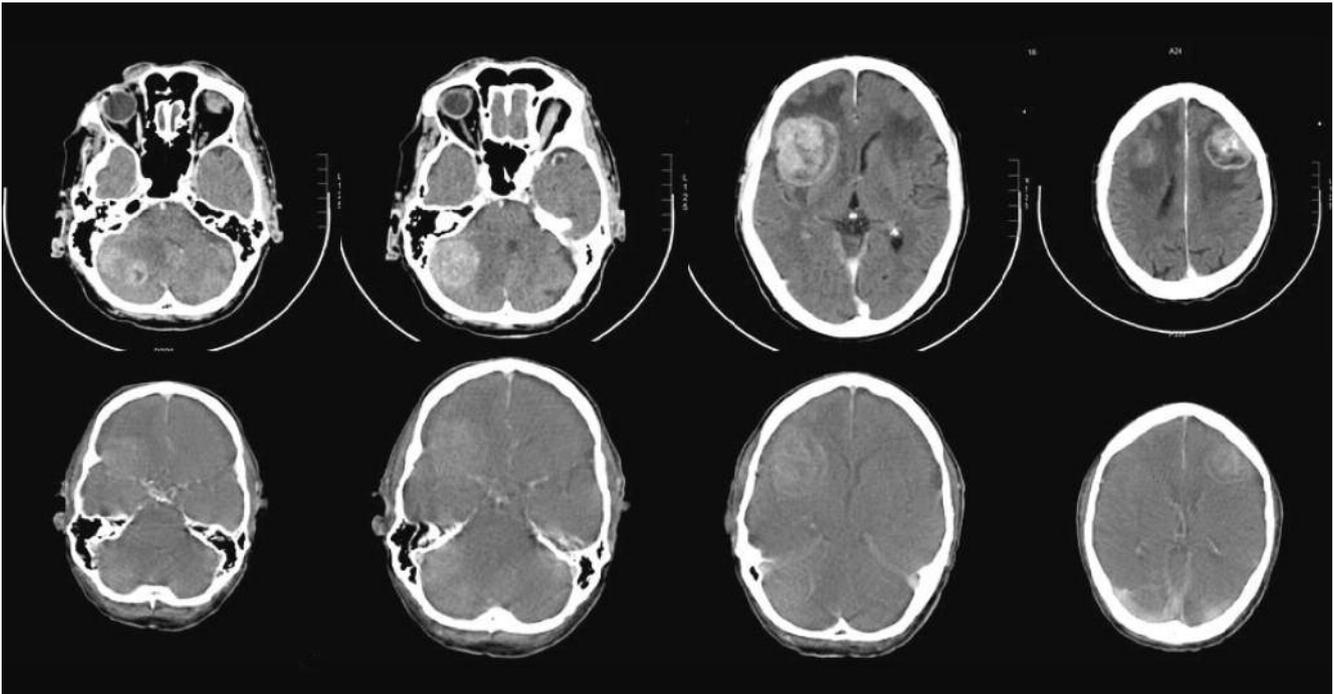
67-year-old man with SCLC in the left upper lobe. Patient developed neurological symptoms. Diagnostic brain CT (upper row) showed multiple brain metastases: two right cerebellar, one right frontal and one left frontal. All these metastases are surrounded by oedema. The CT of the integrated PET/CT (lower row) showed also brain metastases but could not demonstrate one right cerebellar metastasis (first image).
